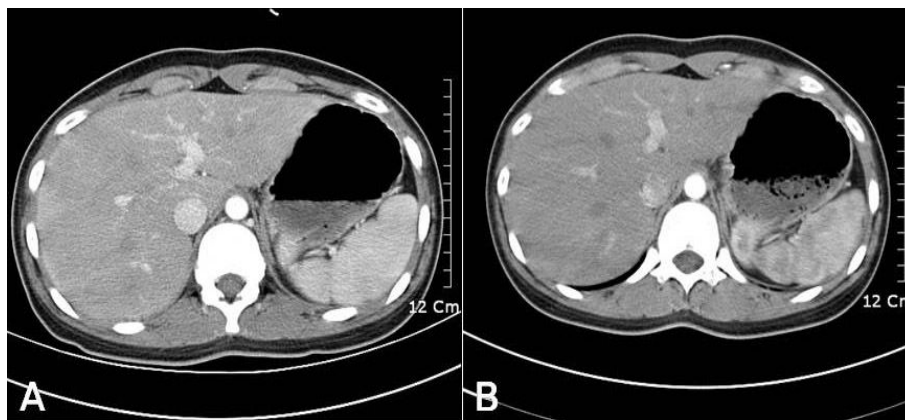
(A) Arterial-phase axial computed tomography (CT) scan shows an enhanced hepatic capsule along the right hepatic surface. (B) Portal-phase CT scan of an equal level shows normal enhancement patterns.
